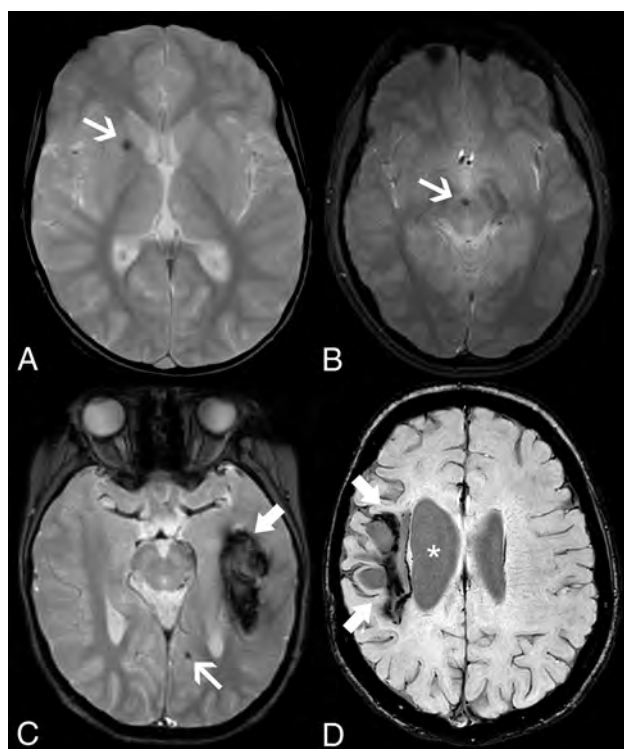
Intracranial hemorrhagic manifestations in adenosine deaminase 2 deficiency. Axial gradient-echo T2-weighted images of patient 4 at 5.8 years of age (A) and patient 11 at 18.3 years of age (B) demonstrate microbleeds in the right lenticular nucleus (arrow) and in the interpeduncular cistern or vessel wall (arrow), respectively. Axial gradient-echo T2-weighted image (C) of patient 1 at 6.1 years of age reveals an acute left temporal hematoma (thick arrow) and a left parameian occipital microbleed (arrow). None of the patients presented with head CT calcifications in the corresponding locations of the microbleeds (not shown). Axial SWI of patient 5 (D) at 16.5 years of age depicts a right frontoparietal hemorrhagic chronic lesion (thick arrows) causing ex vacuo dilation of the lateral ventricle (asterisks).
